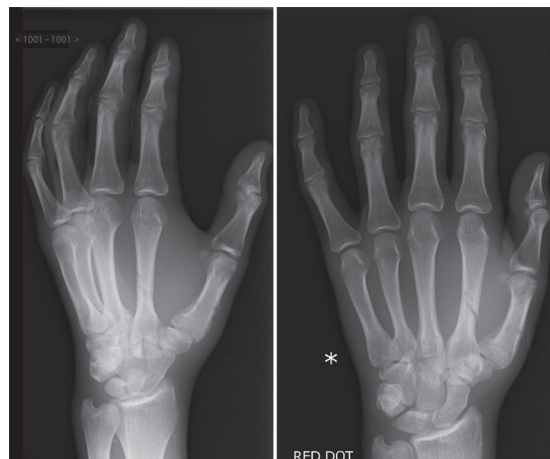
Radiograph demonstrating the adjacent second metacarpal fracture post removal of K-wires
